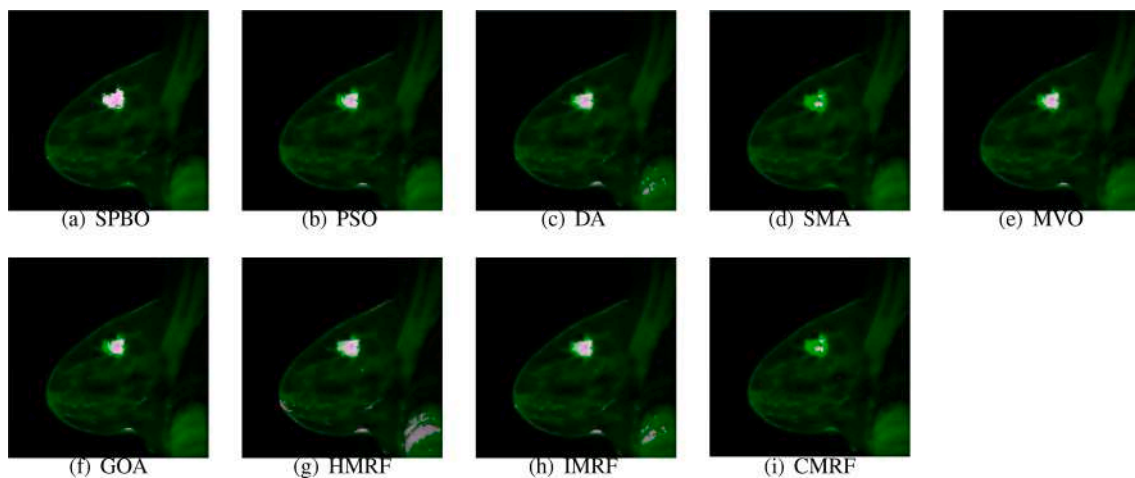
Localized lesions (bright colored spot) in MR images for patient-1 (a) SPBO, (b) PSO, (c) DA, (d) SMA, (e) MVO, (f) GOA, (g) HMRF, (h) IMRF, and (i) CMRF.
